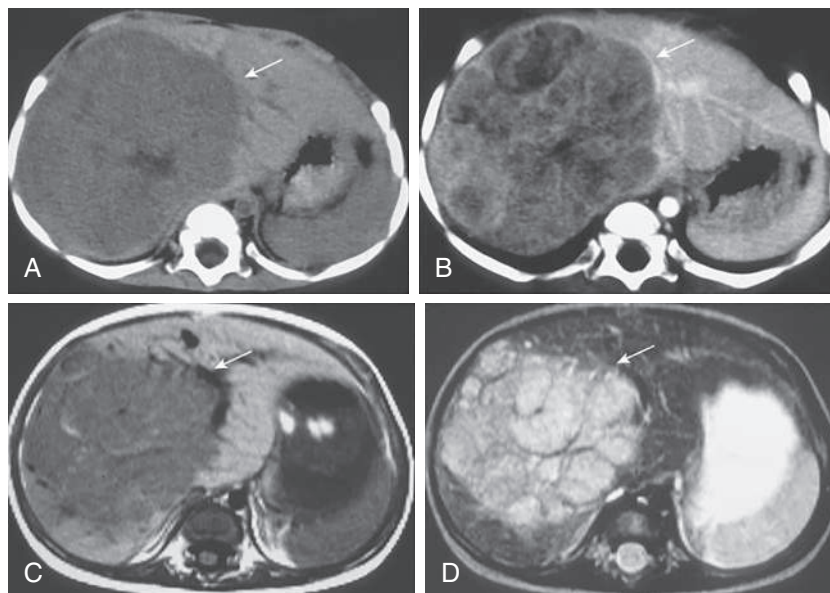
Hepatoblastoma in a 3-yr-old child. A, Pre-contrast CT scan shows well-demarcated, heterogeneous hypodense mass (arrow). B, Postcontrast CT scan shows heterogeneous internal enhancement (arrow). C and D, The mass (arrow) demonstrates heterogeneous hypointensity on T1-weighted (C) and hyperintensity on T2-weighted (D) MR images.
